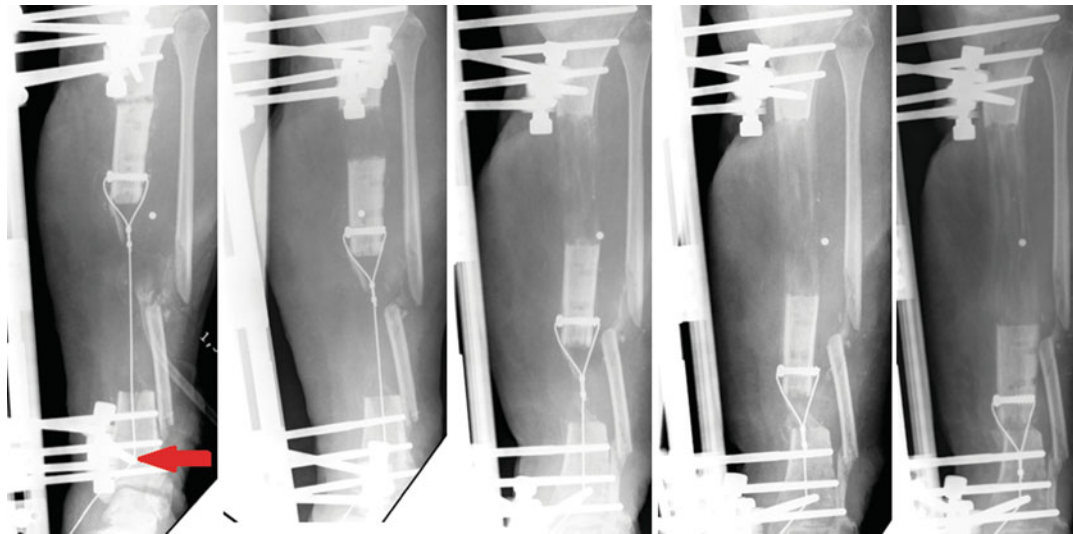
Frontal radiographs of the bone transport, distraction index was 0.75 mm/day
